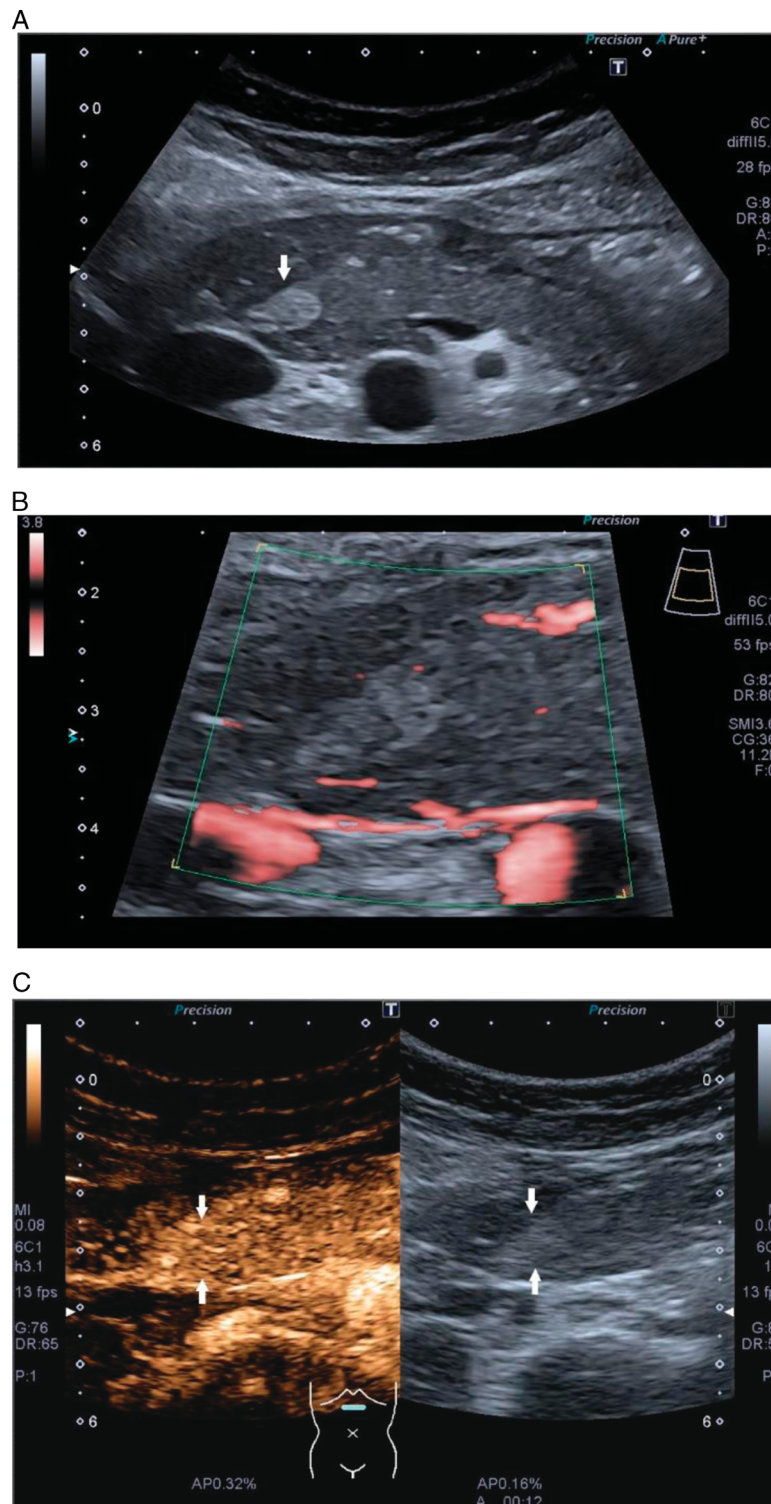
Lipoma. Female, 31 years old. Sonographic incidental finding of an oval, sharply circumscribed, homogeneous, hyperechoic lesion on the pancreatic head. No evidence of macrovessels on power Doppler. On CEUS, the lesion is isoenhanced. EUS-guided sampling was performed without evidence of a solid tumor. Differential diagnosis with the very distinct smooth boundary, a lipoma is possible. CEUS: contrast-enhanced ultrasound.
